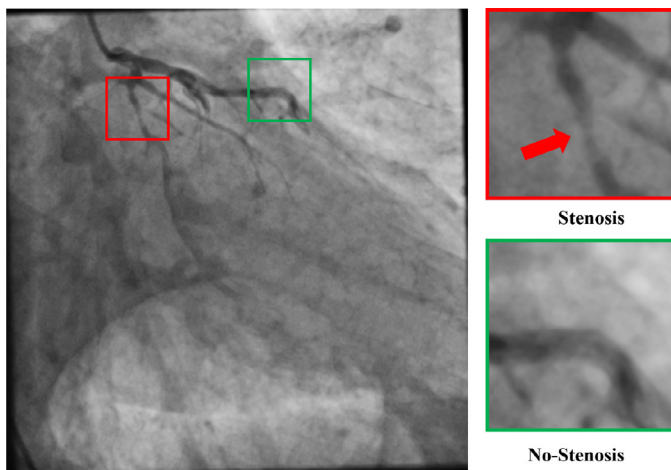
The XCA test requires injecting a contrast agent into the coronary artery tree, revealing the arterial structure easily observed on X-ray images. A visible stenosis region is marked in a red box, including a red arrow indicating the position of the stenosis and a non-stenosis region in green.
